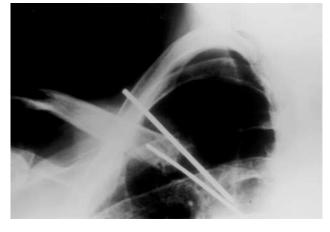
Postero-anterior chest radiograph showing intrathoracic migration of one of the K-wires now lying in the anterior mediastinum
